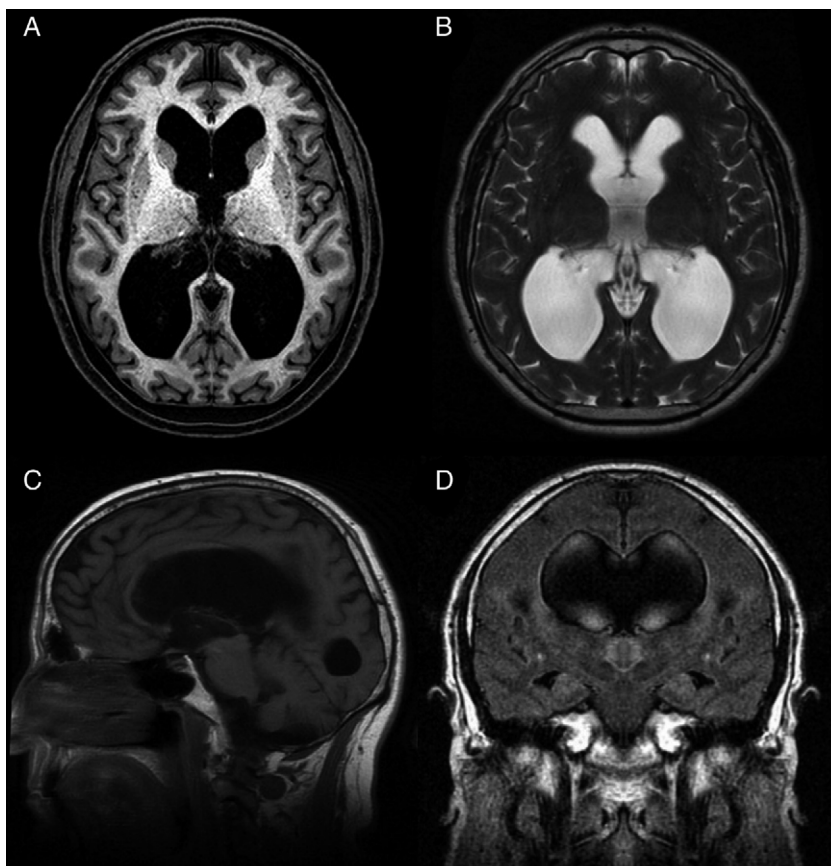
Preoperative MR image of a patient with idiopathic normal-pressure hydrocephalus who responded well to ventriculo-peritoneal shunting. (A) Axial T1-weighted sequence. Moderate dilatation of the lateral ventricles and the third ventricle. (B) Axial T2-weighted sequence. CSF flow artefacts in the third ventricle; absence of hyperintensity at the periventricular and subcortical levels. (C) Sagittal T1-weighted sequence. Descent of the third ventricle floor, rounding of the third ventricle, and decreased mamillopontine distance. The image shows no obstruction in the aqueduct of Sylvius that may explain ventricular dilatation. (D) Coronal FLAIR sequence. Typical pattern of effacement of convexity sulci, especially in the midline. The CSF flow signal void on the T2-weighted sequence extends towards both Monro foramina, reaching the lower and middle portions of the ventricular cavities. Absence of periventricular and subcortical hyperintensities.
